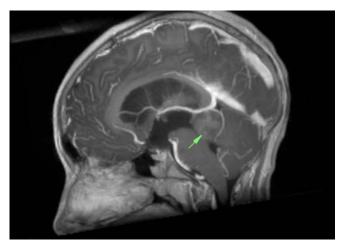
Head MRI with MPR reconstruction in the sagittal plane shows a ganglioglioma causing hydrocephalus.
